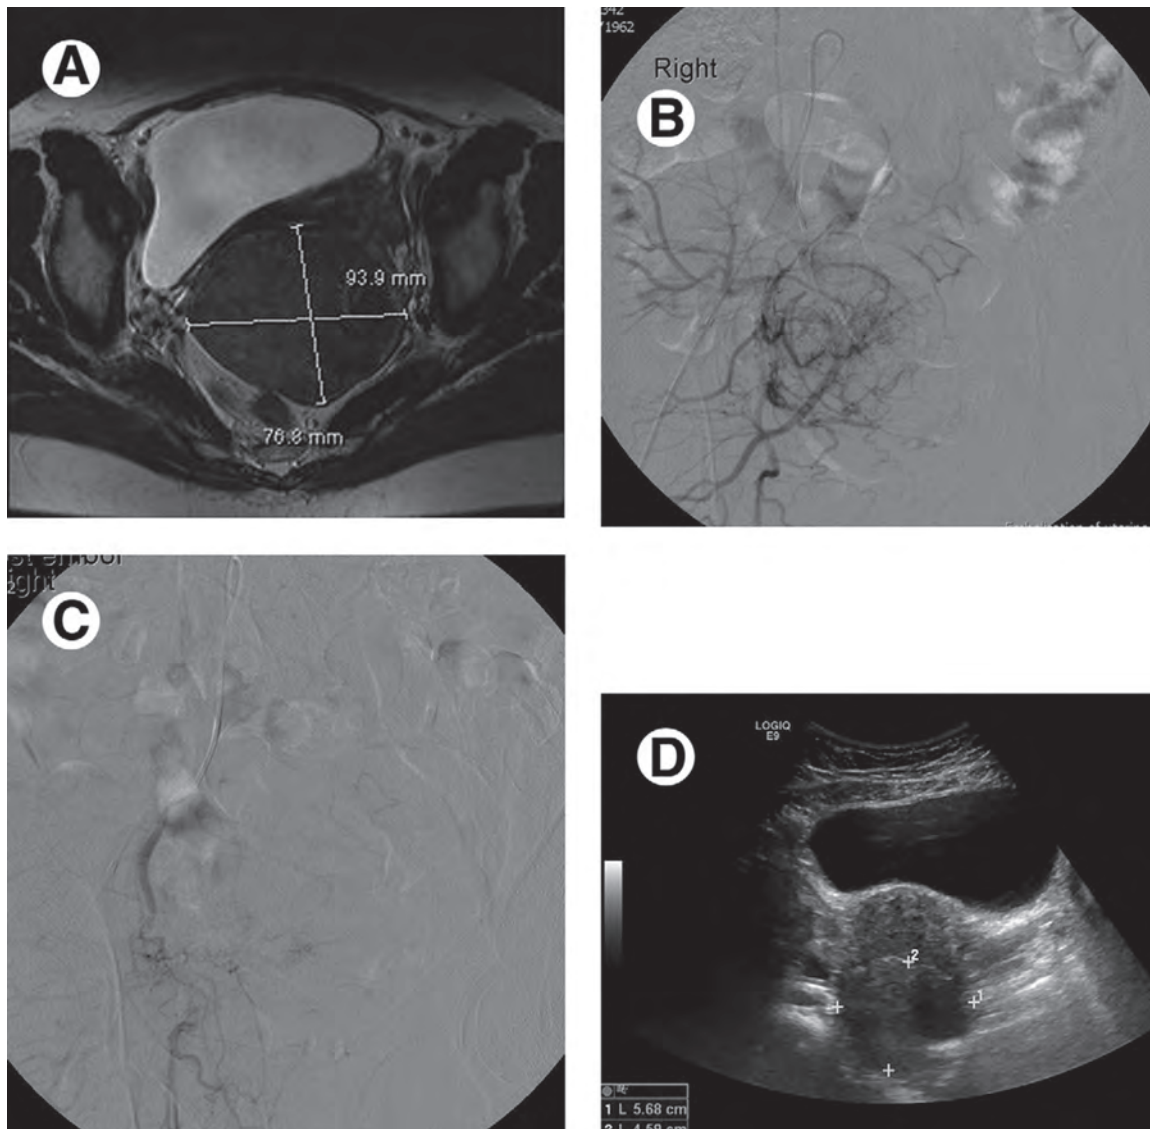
Embolization of uterine fibroid. Axial T2-weighted MRI (A) shows a large intramural fibroid. Angiographic images before (B) and after (C) embolization images showing reduced vascularity of the fibroid after the procedure. Follow-up ultrasonographic image (D) shows reduced size of the fibroid. (From Griffin Y, Sudigali V, Jacques A. Radiology of benign disorders of menstruation. *Semin Ultrasound CT MR*. 2010;31[5]:414–432.)
